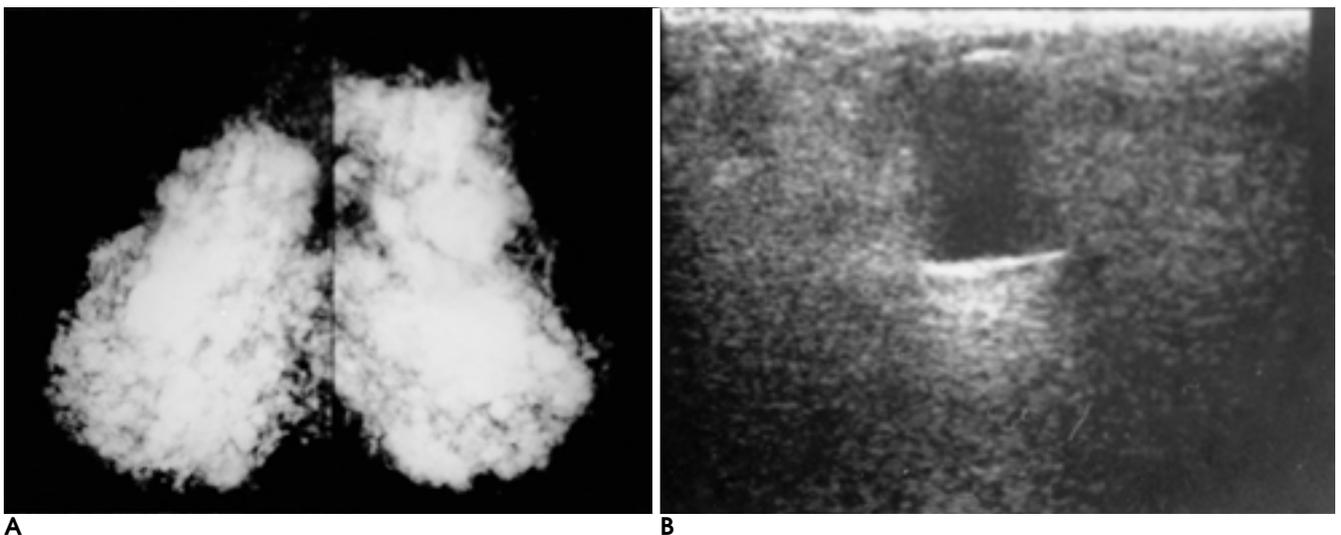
Mammogram and sonogram of siliconomas.
